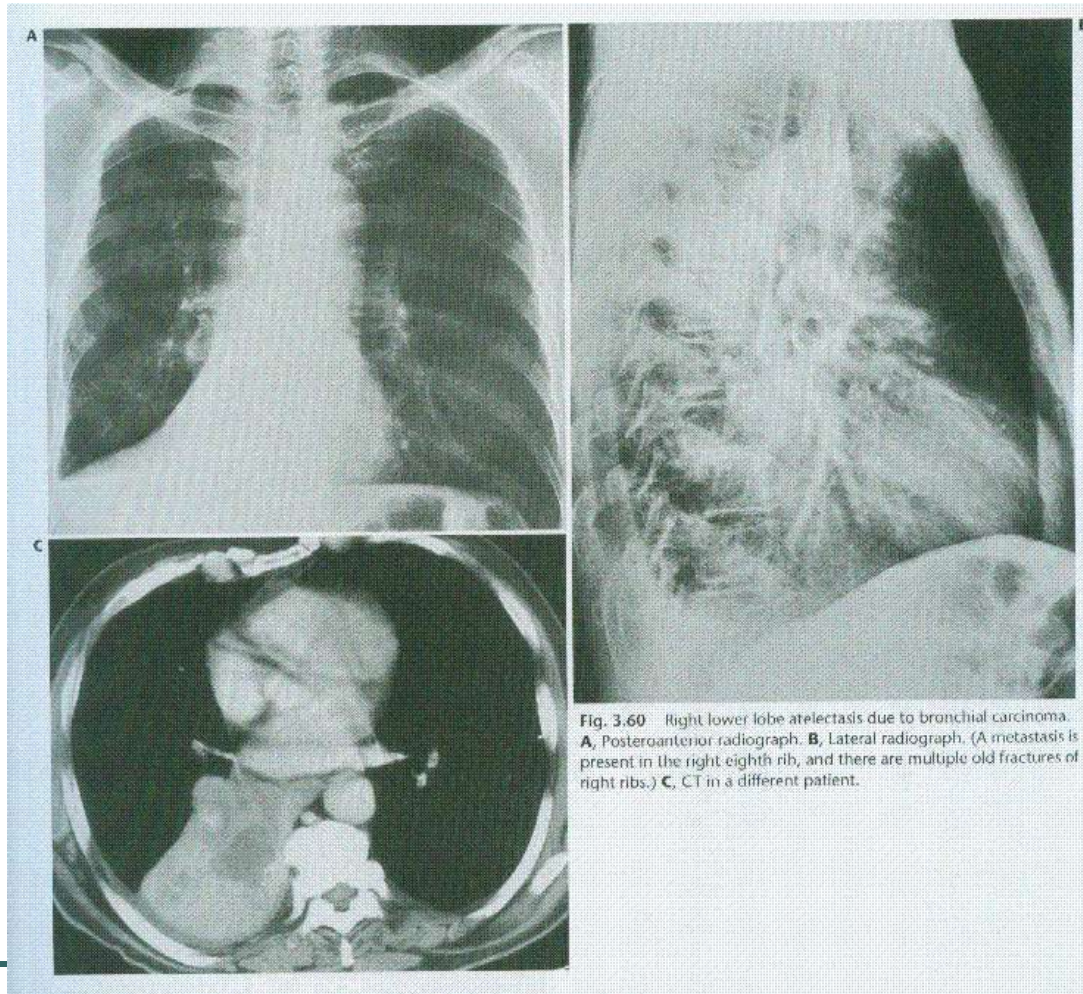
Right lower lobe atelectasis due to bronchial carcinoma. A, Posteroanterior radiograph. B, Lateral radiograph. (A metastasis is present in the right eighth rib, and there are multiple old fractures of right ribs.) C, CT in a different patient.
